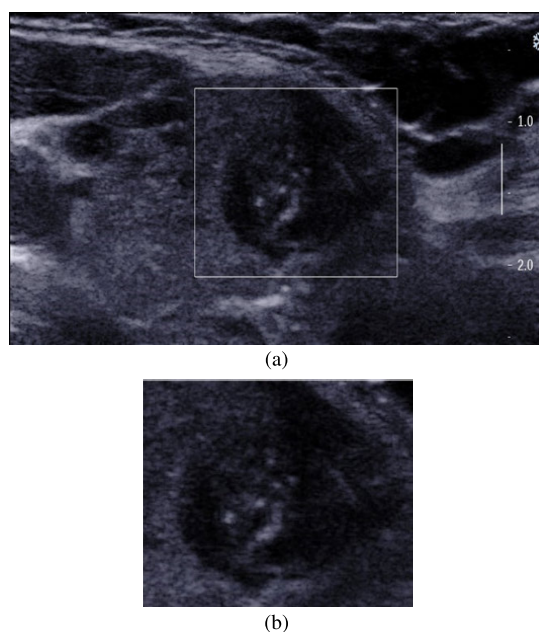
Examples of the ultrasound images with thyroid nodule. (a) The longitudinal thyroid nodules. (b) The transverse thyroid nodules.
